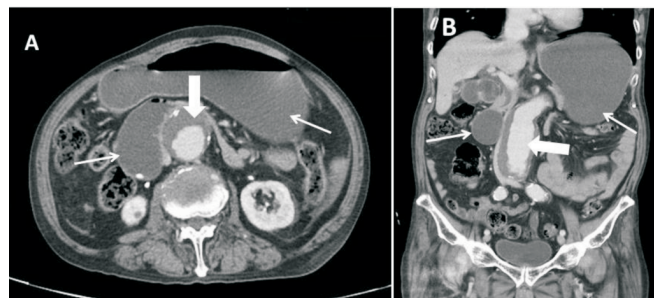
(A and B) Abdominal computed tomography showing the abdominal aortic aneurysm with intramural hematoma (big arrows) and a dilated stomach and partial duodenal obstruction (arrows).
